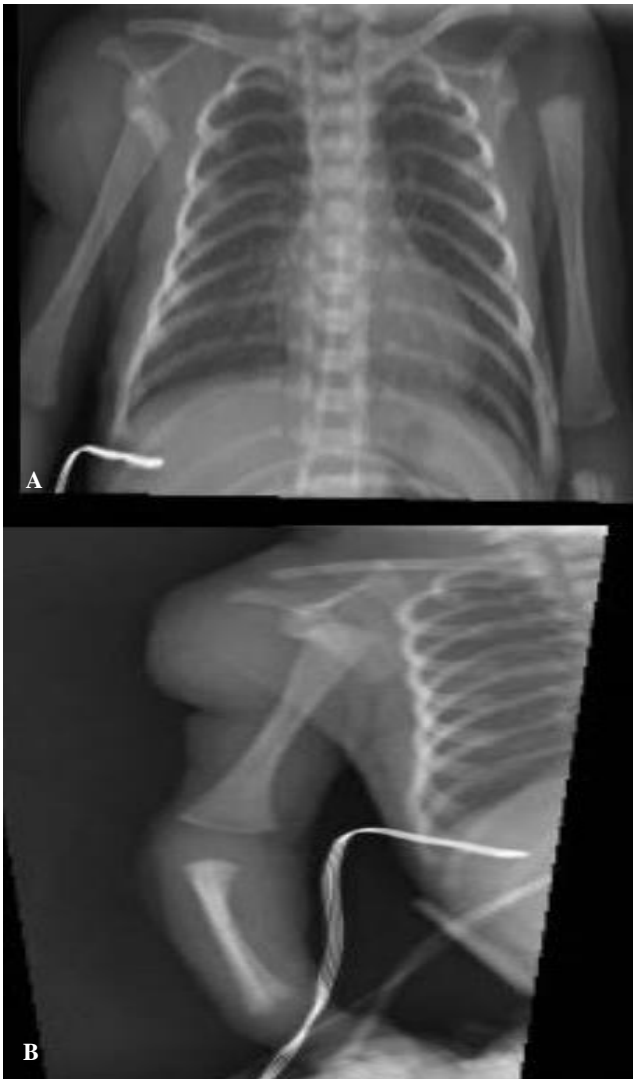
(A and B): Right arm x-ray, first day post-partum.
